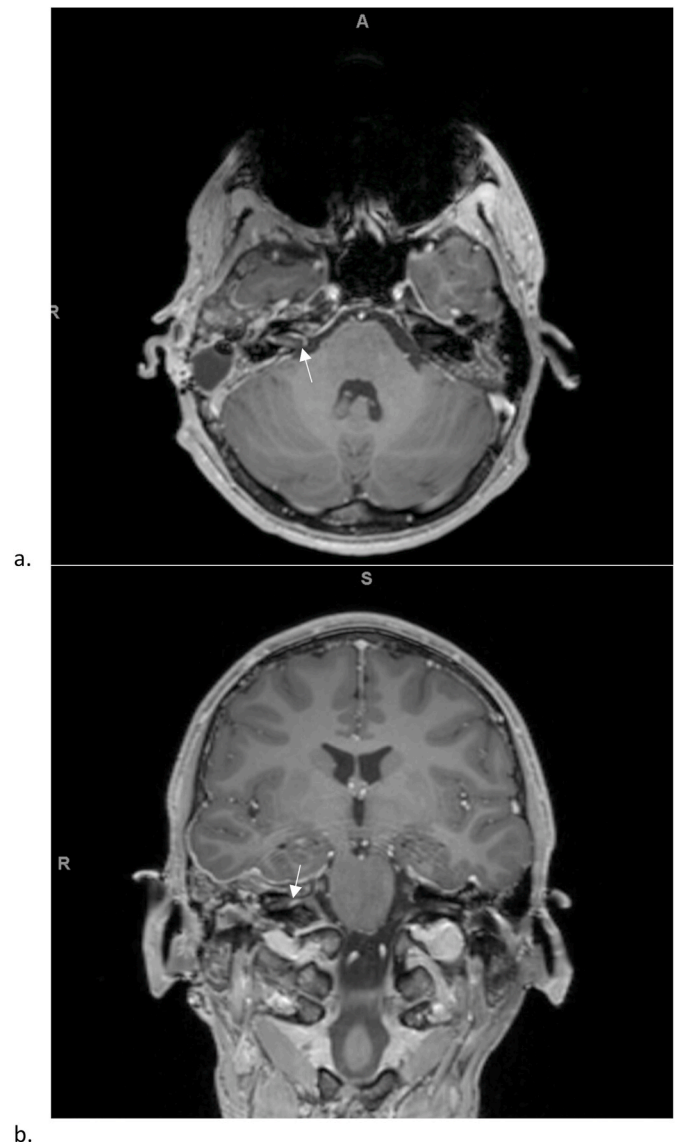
Axial (a) and coronal (b) cuts of a T1-weighted post contrast brain magnetic resonance imaging showing right facial nerve enhancement in the internal auditory canal (white arrow).
